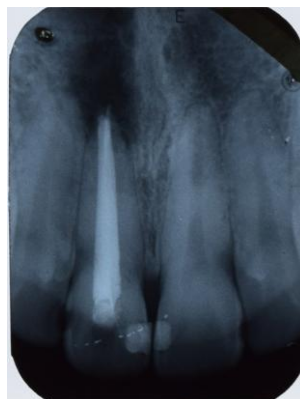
Radiograph of 11 immediately after obturation
